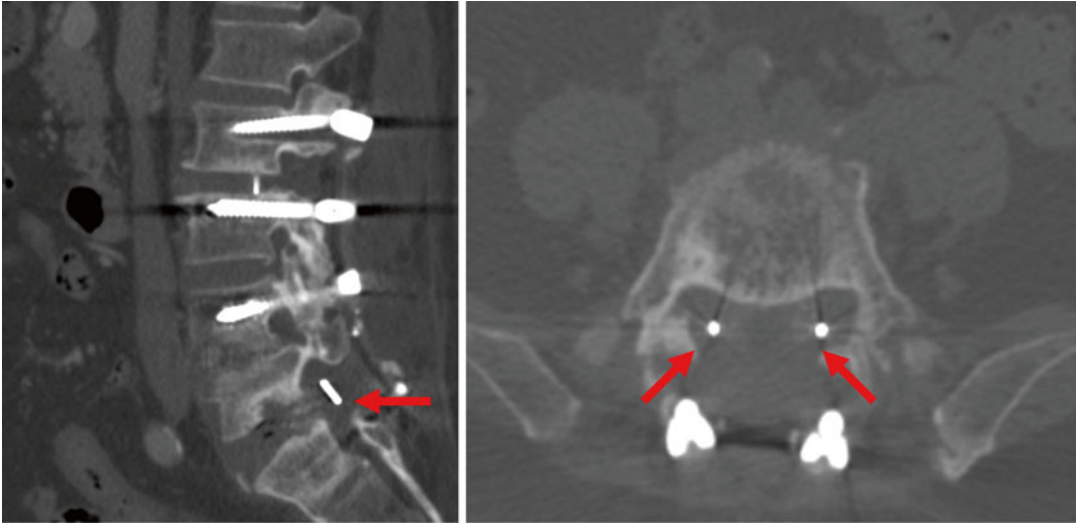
CT scan with sagittal and axial views that demonstrate bilateral cage retropulsion into the recess (*red arrows*). The patient suffered from bilateral sciatica, which necessitated reoperation for cage repositioning
